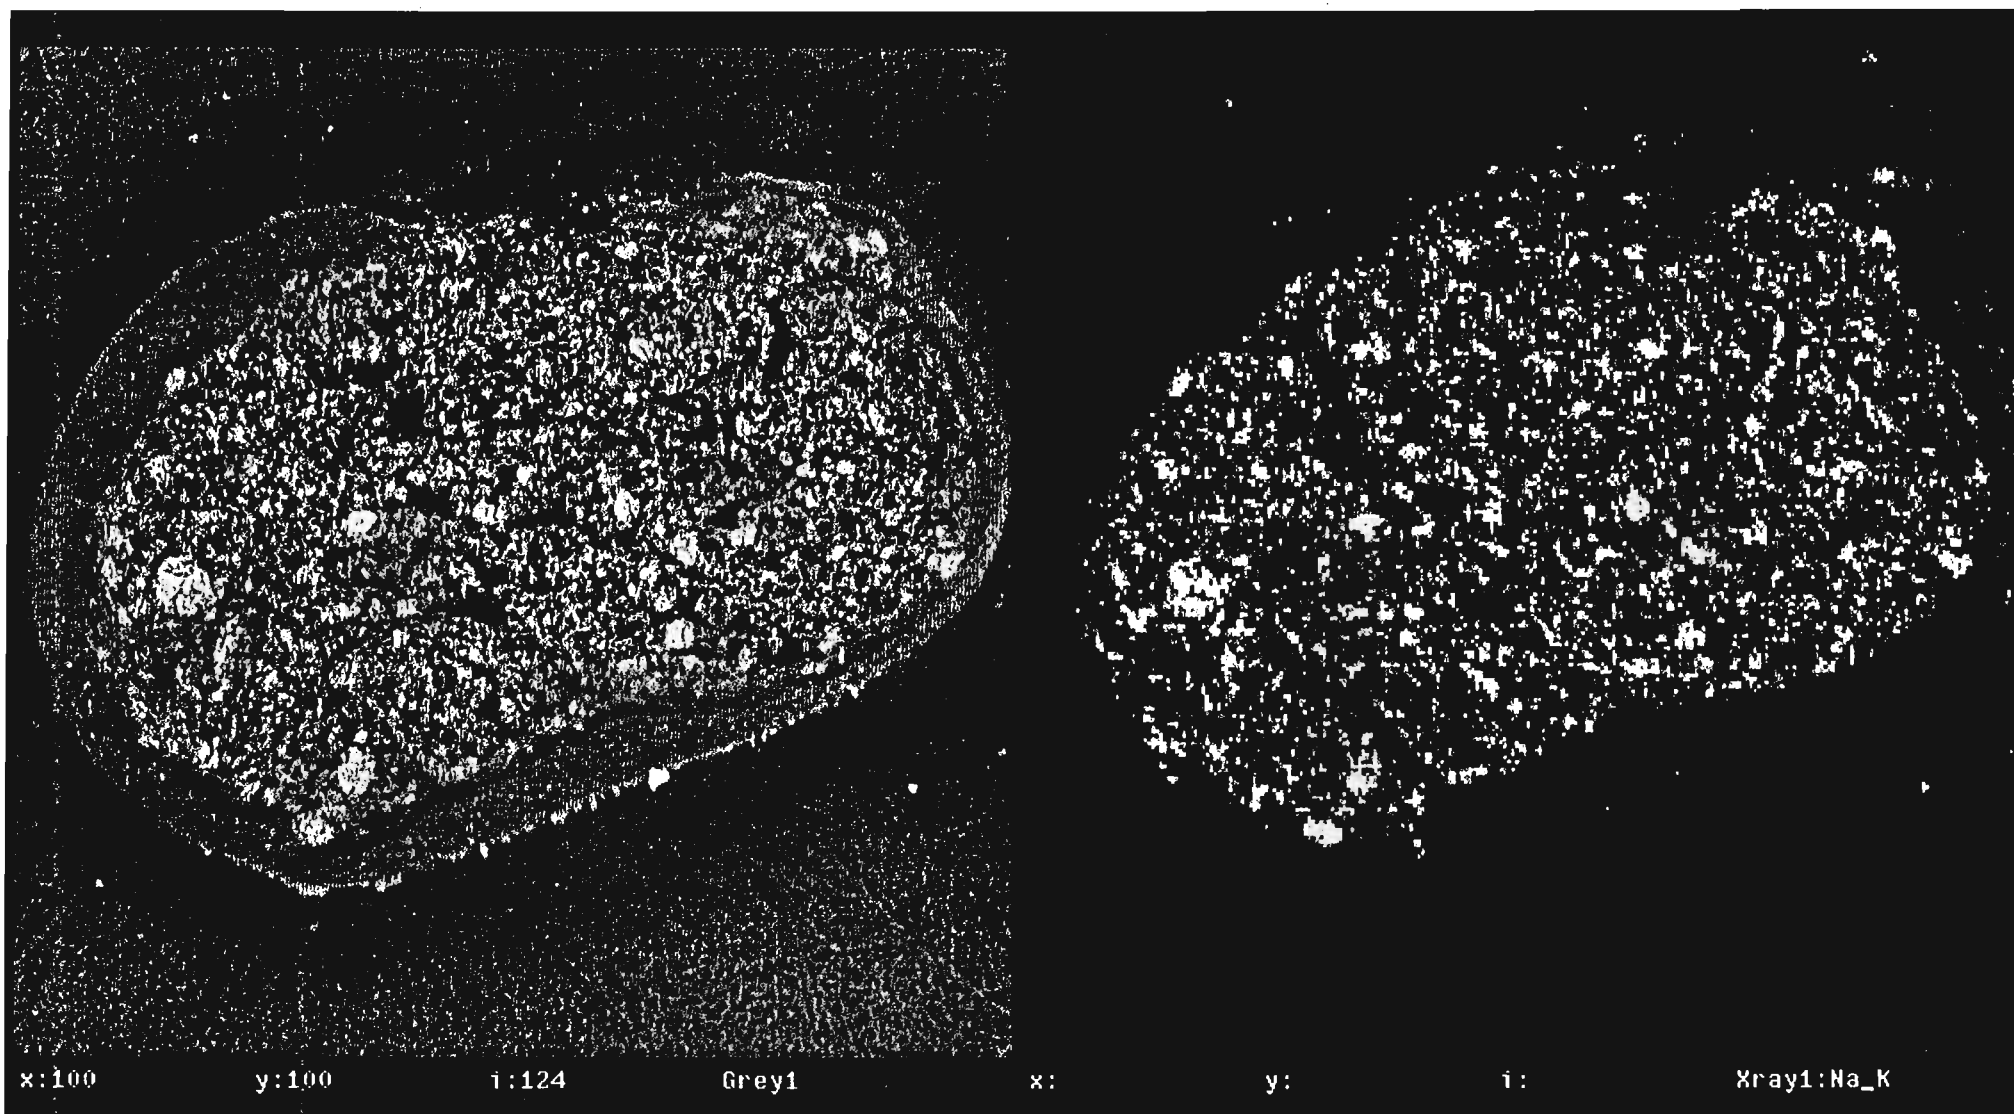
X-ray Map of a Cross-section of a Diclofenac Sodium-Ethylcellulose Microcapsule (Batch DE1)
